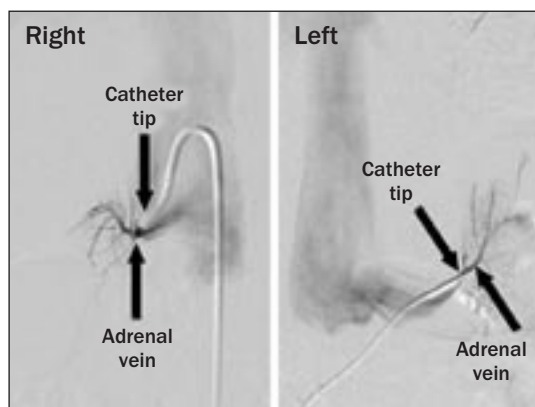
Images of adrenal venous sampling performed in the patient with primary aldosteronism whose computed tomographic scan is shown in Figure 1. Radiographs show catheters placed in the right and left adrenal veins.
